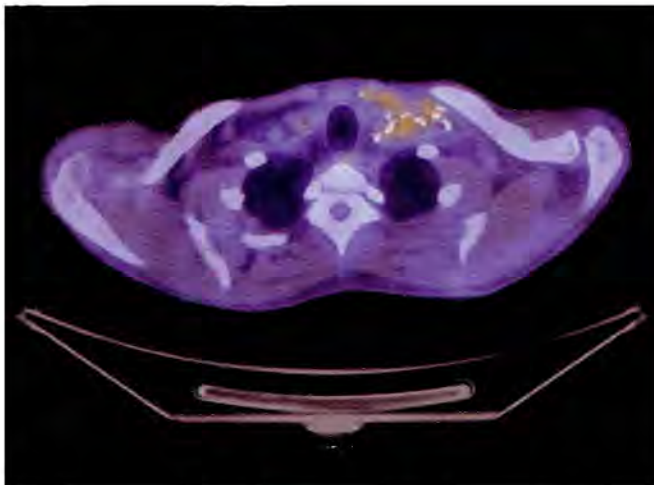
Postsurgical changes and expected inflammatory FDG accumulation are observed in the postoperative bed in the left neck.
